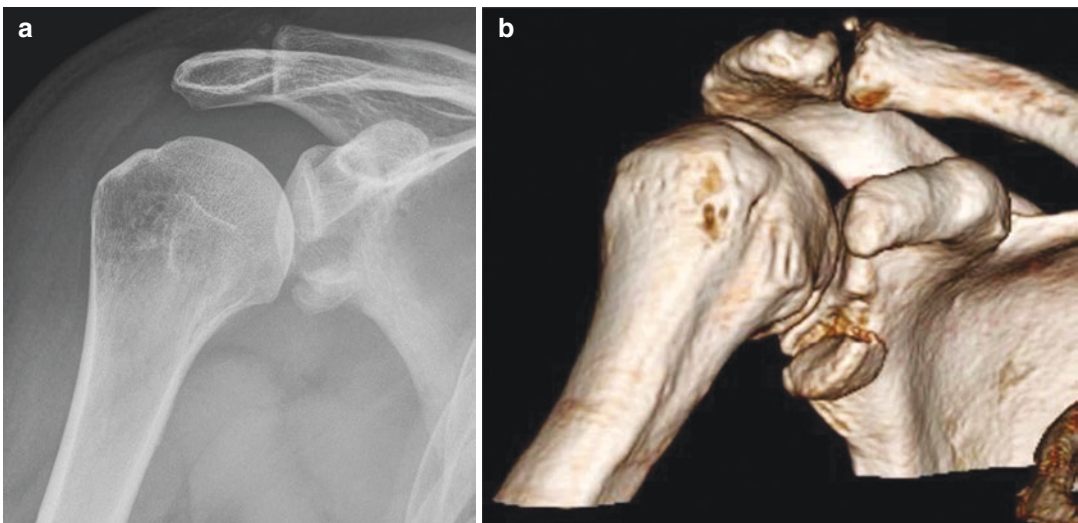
Fracture of the anteroinferior glenoid rim; radiograph (a) and CT scan (b)
